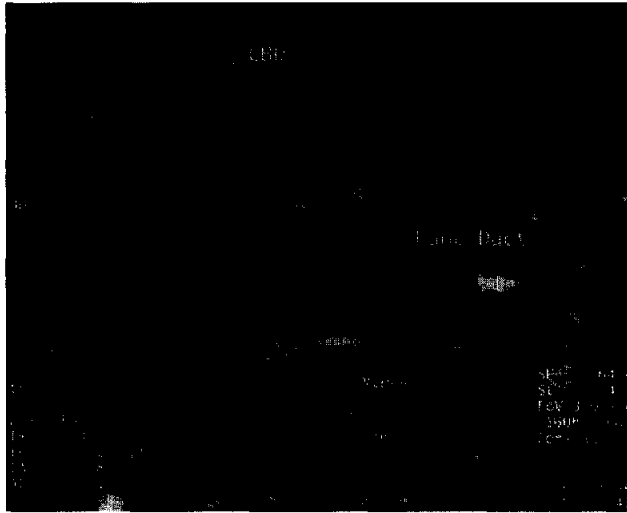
Thin-section image from an MRCP using a heavily T2-weighted sequence. The pancreatic (*Panc*) duct and common bile duct (*CBD*) are dilated (arrows) and a mass (arrow) is seen at the confluence of the ducts.
